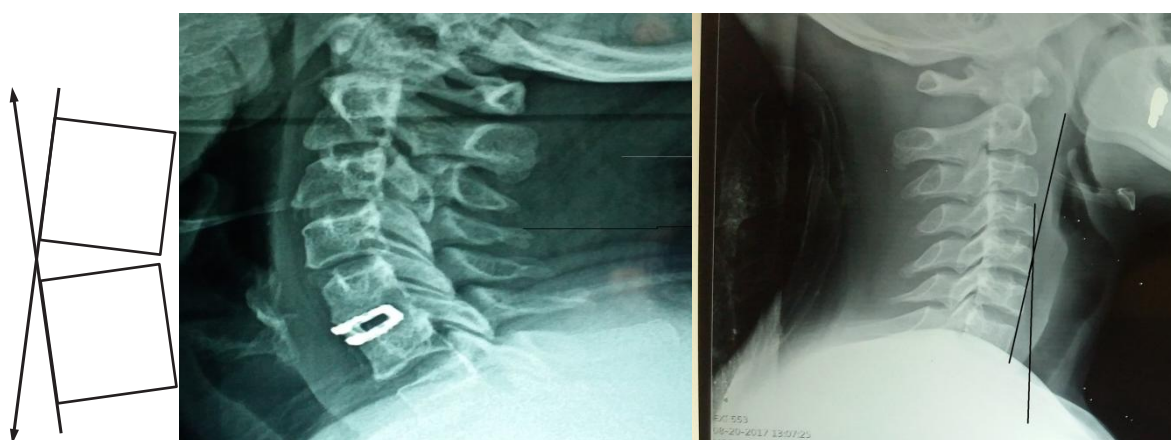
Anterior Cervical Diskectomy and Fusion Cage X-Ray Image with cervical normal cervical lordosis
